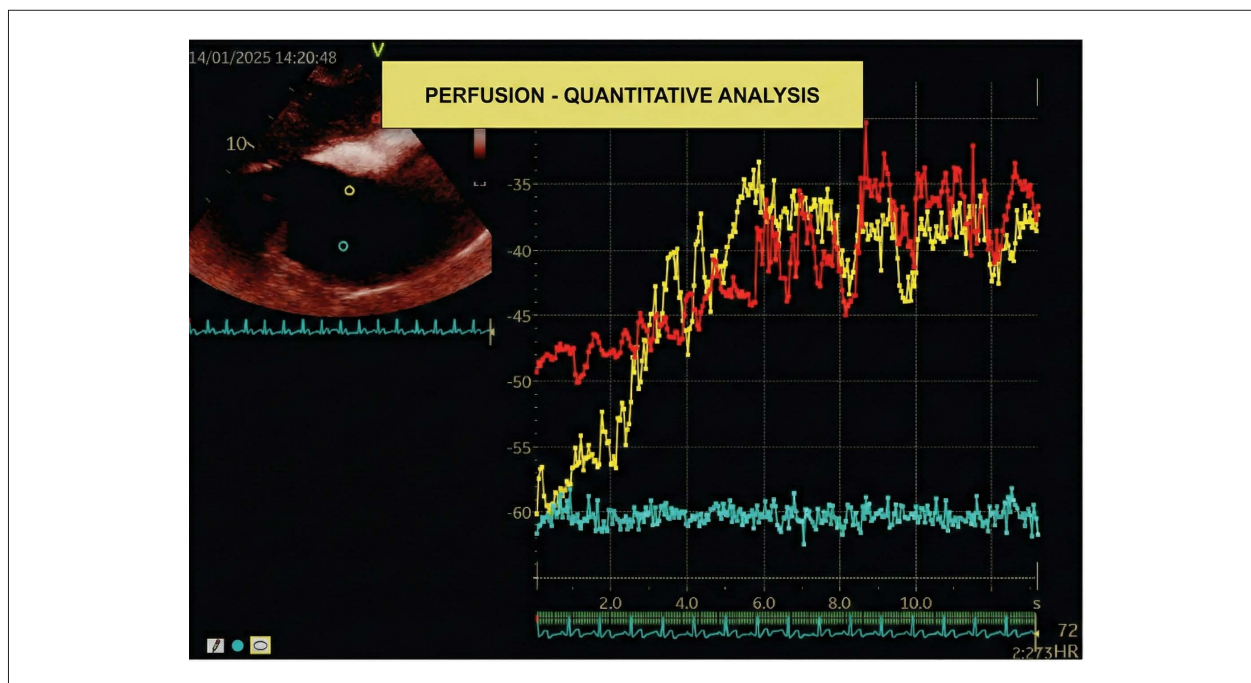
Subcostal view. Cardiac paraganglioma. Quantitative analysis of the mass perfusion with an ultrasound-enhancing agent (contrast) - in yellow, the peripheral perfusion of the mass; in red, perfusion of the liver tissue for comparison; in blue, the absence of perfusion in the (necrotic) center of the mass.
